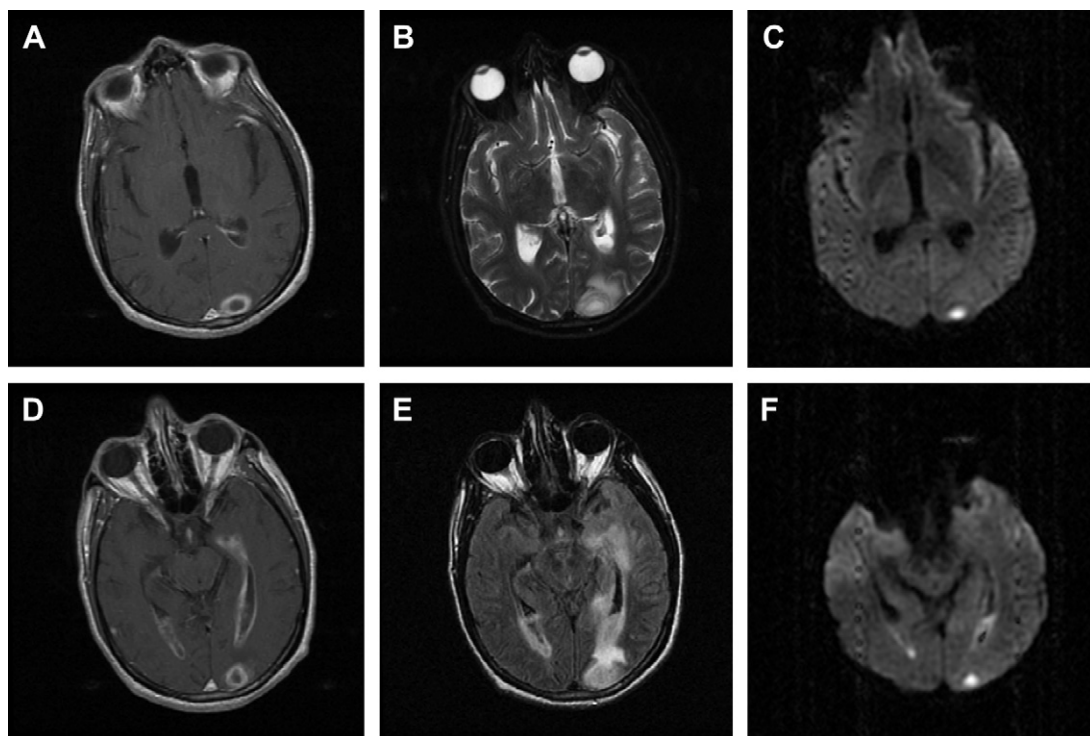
A 57-year-old male alcoholic who presented with altered mental status. (A–C) Axial T1 postcontrast, T2, and diffusion-weighted sequences demonstrate a characteristic left occipital abscess with rim enhancement, central T2 hyperintensity, and bright signal on the diffusion-weighted sequence, which was confirmed to represent true restricted diffusion by ADC maps. There is surrounding mild vasogenic edema. (D–F) Axial T1 postcontrast, FLAIR, and diffusion-weighted sequences demonstrate associated intraventricular rupture with ventriculitis as demonstrated by abnormal ependymal enhancement, and layering debris in the ventricular system that restricts diffusion. (Courtesy of William Delfyett, MD, University of Pittsburgh.)
